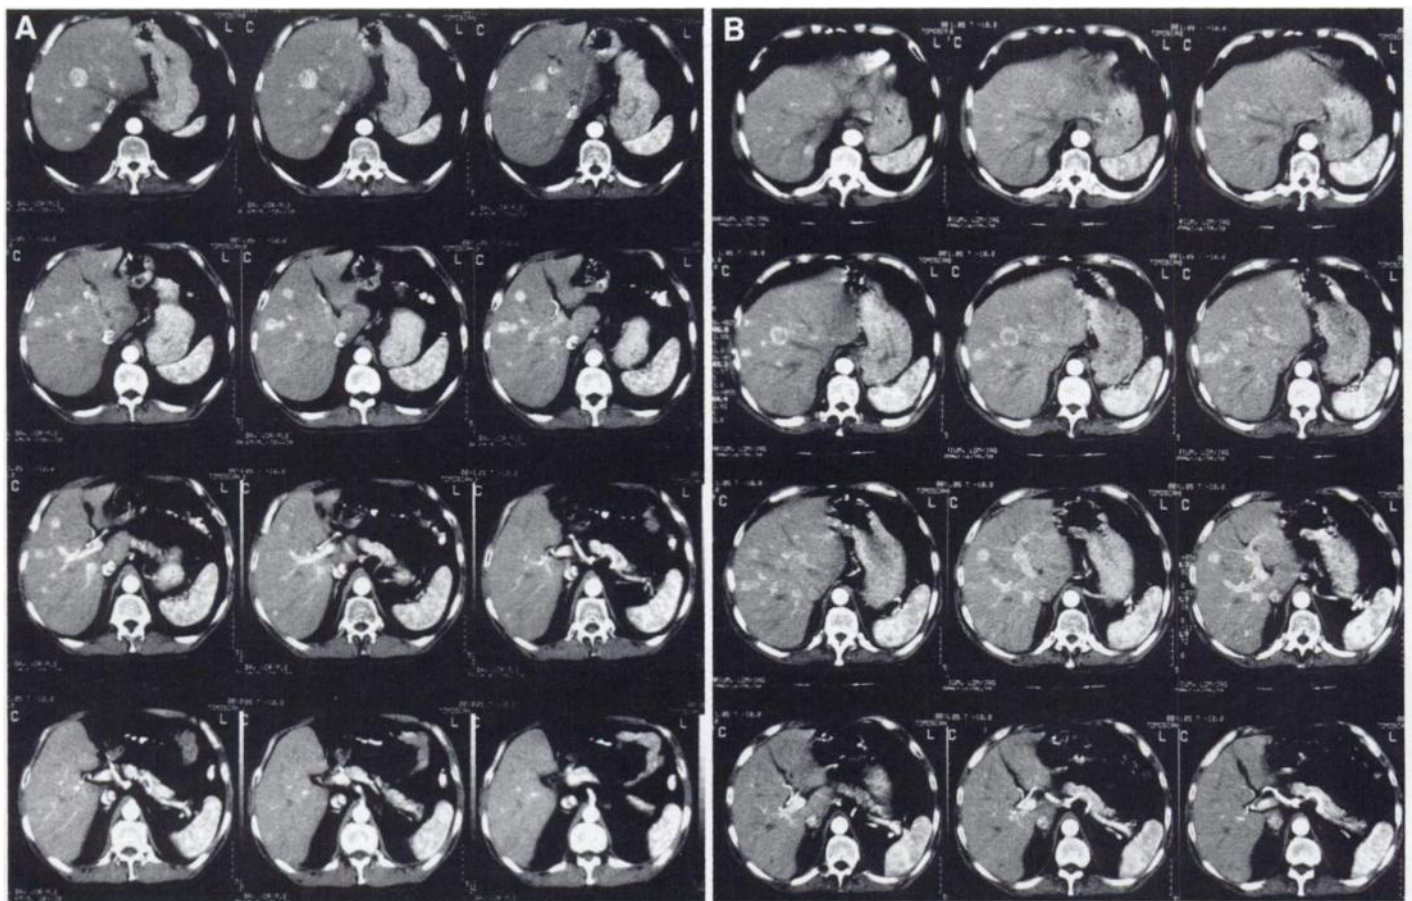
CT of liver and abdomen before (A) and after (B) four treatment cycles with ^{90}Y -DOTA-lanreotide.
